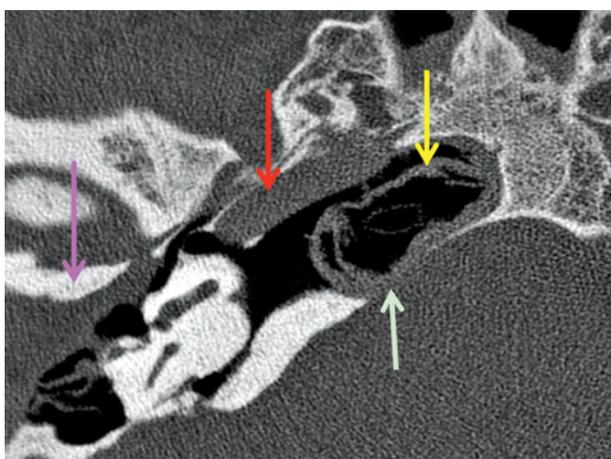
Axial CT showing a cholesteatoma in the petrous apex (yellow arrow); carotid artery dehiscence into petrous apex (red arrow); dehiscence of the medial wall of the petrous apex (green arrow). There is a previous mastoidectomy defect with recurrent cholesteatoma (pink arrow).
